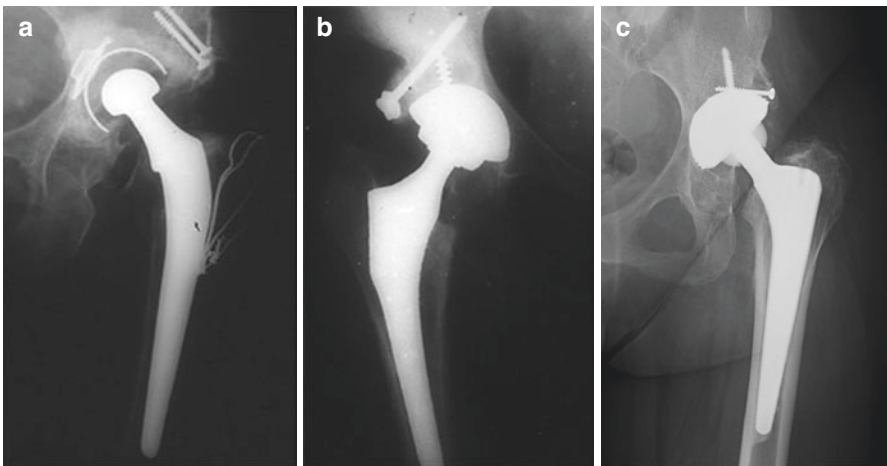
(a–c) Radiographs show structural autograft taken from the femoral head to reconstruct the acetabular roof in developmental dysplasia of the hip in cemented and cementless total hip arthroplasties. We can see good trabecular remodelling in all hips
